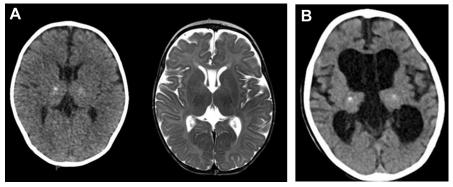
(*A*) Axial non–contrast-enhanced computed tomography (CT) and matching axial T2weighted MR images of a 5-year-old boy with confirmed Aicardi-Goutieres syndrome. Subtle hyperdense calcifications are noted within the bilateral thalami. The calcifications are barely visible as T2-signal alterations on the matching MRI. (*B*) Follow-up non–contrastenhanced CT 2 years later shows progressive, global white matter volume loss with ex vacuo widening of the ventricular system and mild widening of the subarachnoid space.
